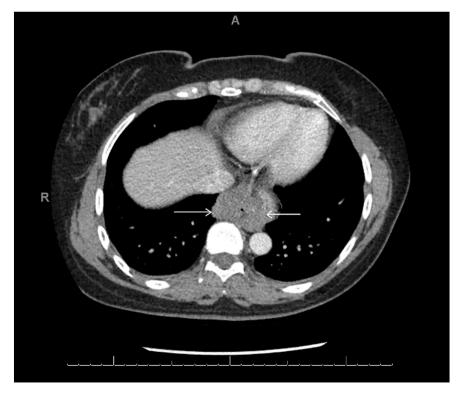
CT Scan. 6.0 × 4.0 × 3.0 cm gastroesophageal junction mass seen in the submucosa and muscularis propria, displacing the esophagus to the left.
